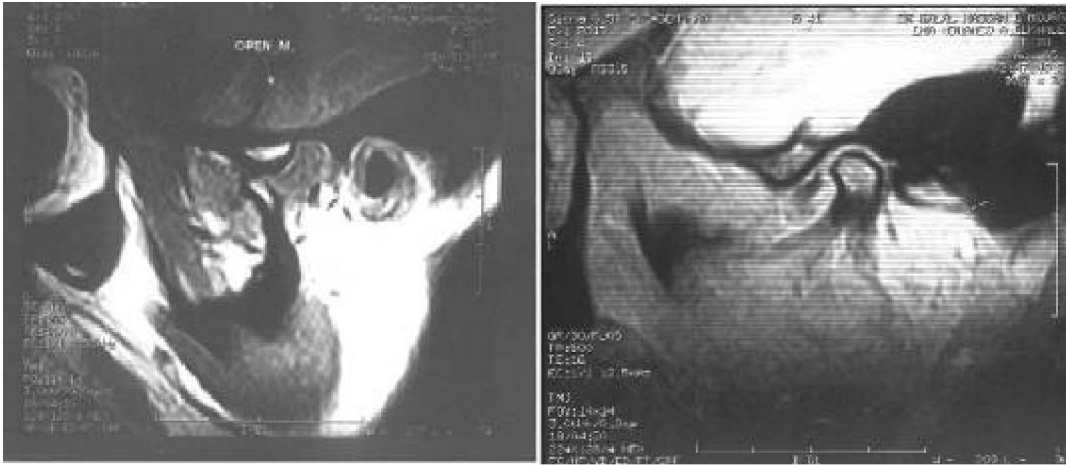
Sagittal MR image (TR= 500msec; TE=11msec) of the left TMJ showing anterior disc displacement without reduction (left; closed mouth. Right; opened mouth
